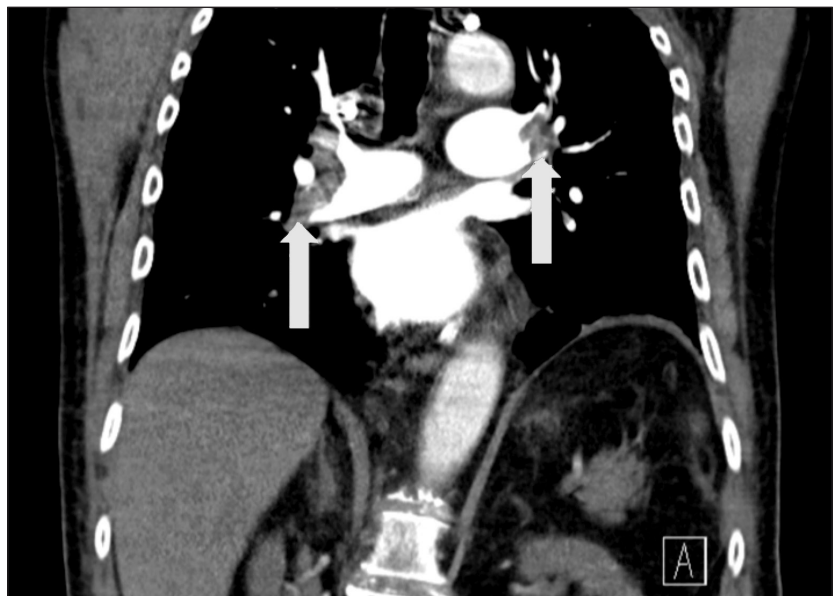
Chest computer tomography angiography (CTA) performed due to suspected pulmonary embolism. The CTA reveals bilateral extensive pulmonary emboli along the distal right and left main pulmonary arteries (red arrows).
